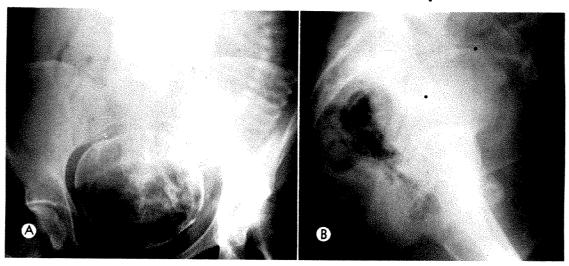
Case II. (A) Anteroposterior roentgenogram shows a large aggregation of small gas-filled cysts above the symphysis. (B) In the lateral projection, cystic spaces are well demonstrated in the plane of the midpelvis.
